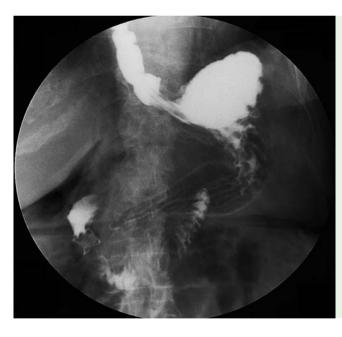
Contrast X-ray study documenting correct placement of the clip.
